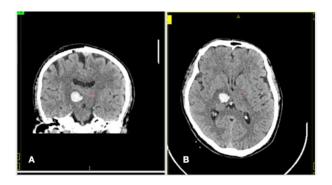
(A) Coronal and (B) axial CT brain showing thalamic hematoma post-lesioning.
